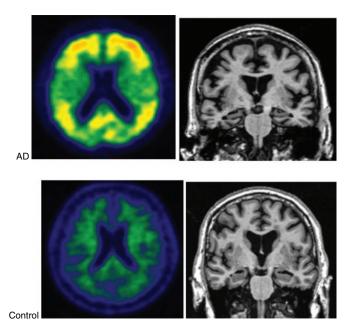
¹¹C Pittsburgh compound B (PiB) scans (left) and magnetic resonance imaging (MRI) scans in a subject with Alzheimer's disease (AD) and a healthy control subject. The ¹¹C PiB scan shows amyloid tracer retention in the red and yellow areas for the subject with AD and no tracer retention in the control subject. The MRI scan in the subject with AD shows generalized atrophy with more focal accentuation in the hippocampus. The MRI scan in the control subject shows age-related changes.
